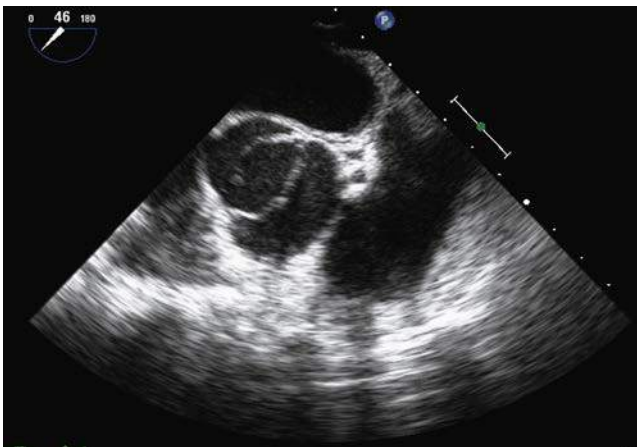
Transesophageal echocardiogram in a short-axis plane of a bicuspid aortic valve.
